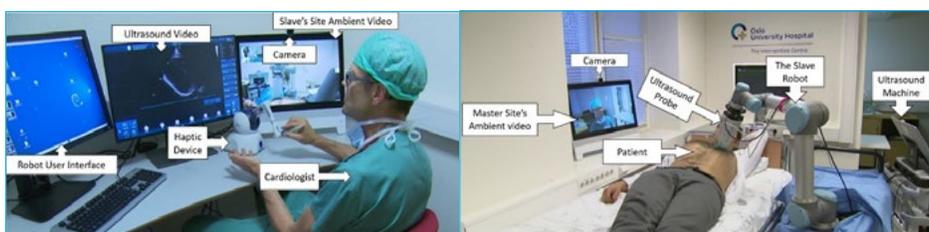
Robot-assisted remote ultrasound examination concept verification.
